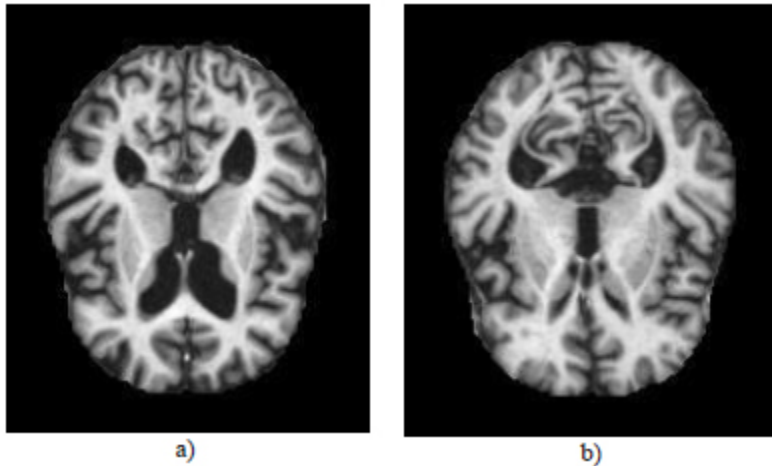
a) Normal MRI b) Alzheimer MRI.
